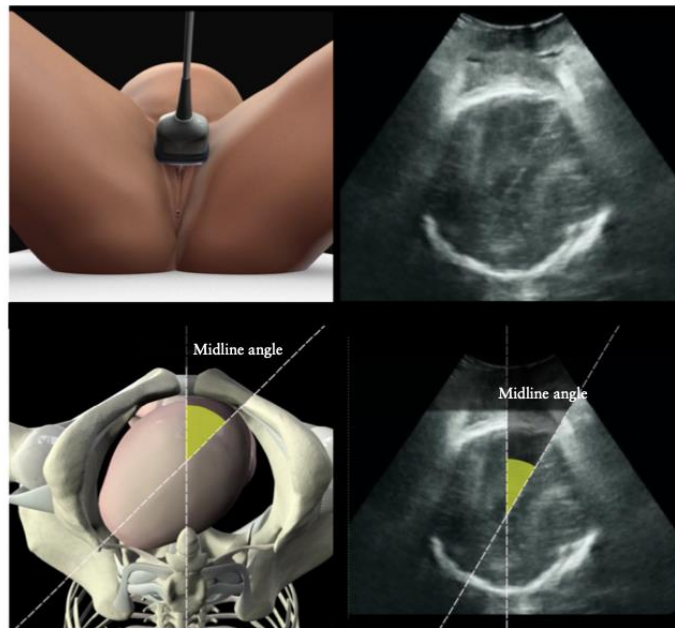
Measurement of midline angle. Showing placement of transducer and how the angle is measured (adapted from ISUOG Practice Guidelines: intrapartum ultrasound)³
